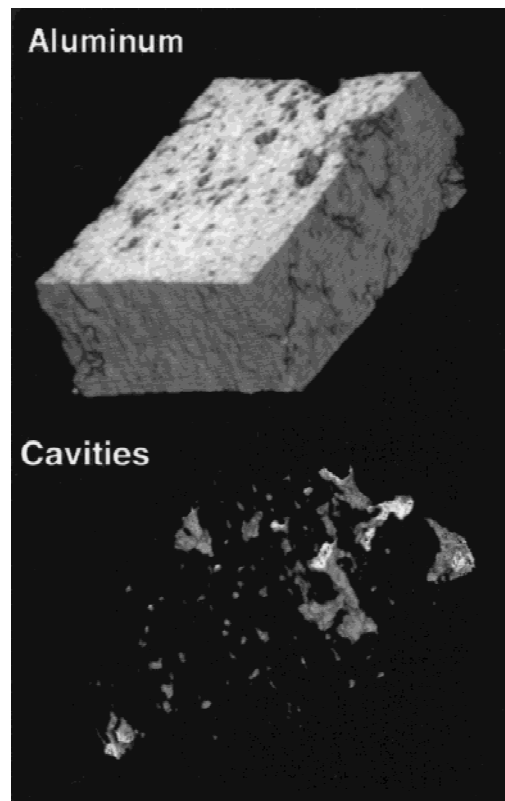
Images of UHR x-ray CT data are shown indicating the aluminum material (top) and the cavities (bottom) between positions b and c indicated in Fig. 1.
